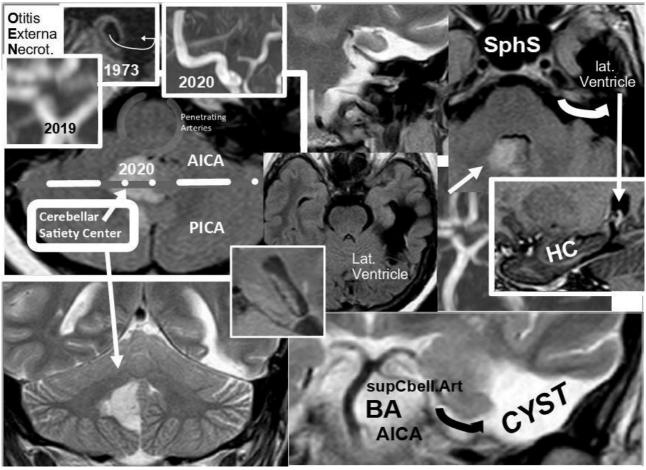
V#1fS1972: The external ear channel defect "1973" allowed the Otitis Externa Necrotisans" to spread as ASOB with a CYST expanding beneath the hippocampus (HC) with the L-lateral ventricle. On a MRI of "2019" a constriction of the R PICA – likely from a MC degranulation in a CIMURAF-"sliding chamber" – was not considered, and "2020" a slow stroke of a putative "cerebellar satiety center" had stopped a hyperphagia since an RTA (2003). Her daughter suffers from hyper-satiety but refused MRI. Fatigue stems from choroid plexus (center) permeabilization promoting intracranial hypertension
